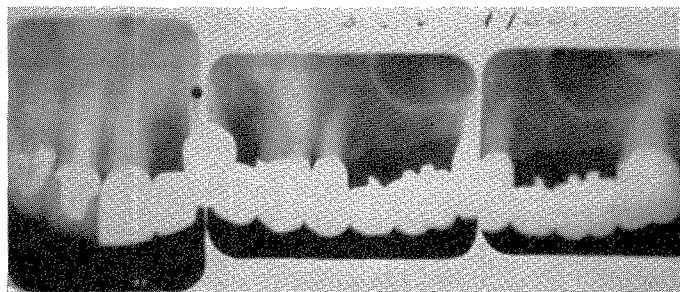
Roentgenogram of a seven-unit fixed bridge inserted in 1955. The patient was a 68-year-old woman. (Figs. 438 to 440 are of the same case.)
